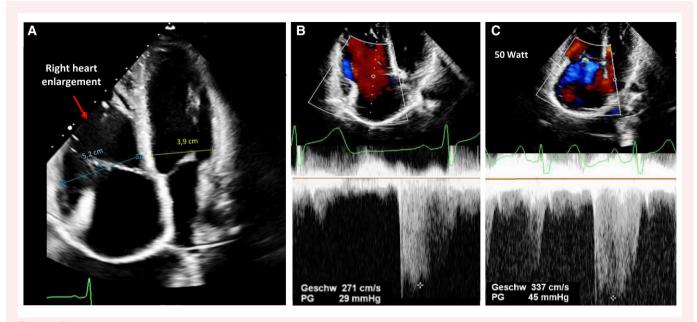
Transthoracic echocardiography pre-atrial septal defect closure. Two-dimensional (A), spectral Doppler at rest (B), and exercise (50 W, C) transthoracic echocardiography.
